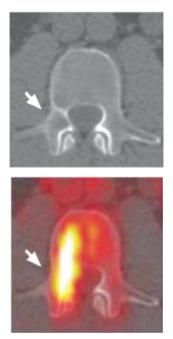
A 50-year-old male with sarcoiodosis. PET/CT images show a lytic lesion with increased FDG activity within the posterior aspect of the L3 vertebral body. (Rajebi et al. Uncommon osseous involvement in multisystemic sarcoidosis. *Ann Saudi Med.* 2009;29:485-6)
